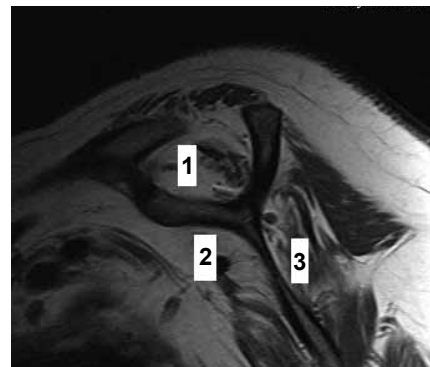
Sagittal MRI cut at the level of the fossa showing marked atrophy of supraspinatus (1), subscapularis (2) and infraspinatus (3) in a massive long-standing tear. There is 'white' fat replacing the atrophied dark muscle. Compare with Fig. 1.
